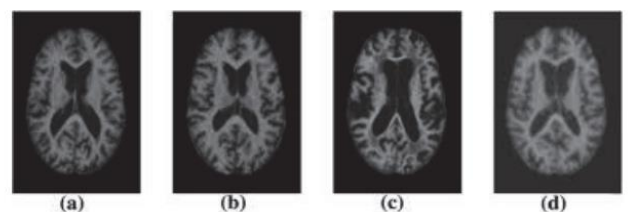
Shows the Brain MRI Images of AD Stages (a) Non Dementia (b) very mild Dementia (c) Mild Dementia (d) Moderate Dementia
